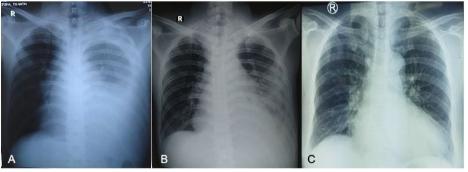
Serial chest X-ray of the patient during the treatment. (A) Initial chest X-ray at hospital admission; (B) after thoracentesis and (C) after two months treatment.
